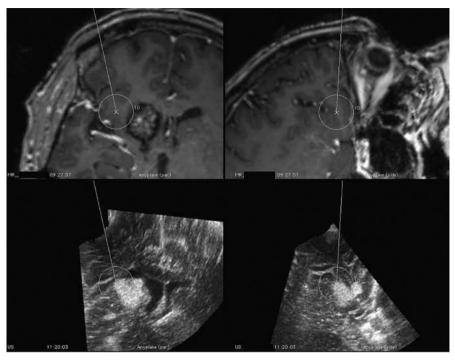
A snapshot from the navigation monitor showing a cavernoma located in the right nucleus caudatus (MR – upper row, US – lower row). The pointer tip is located at the edge of the cavernoma. Notice a considerable inaccuracy in the 3D MRI
